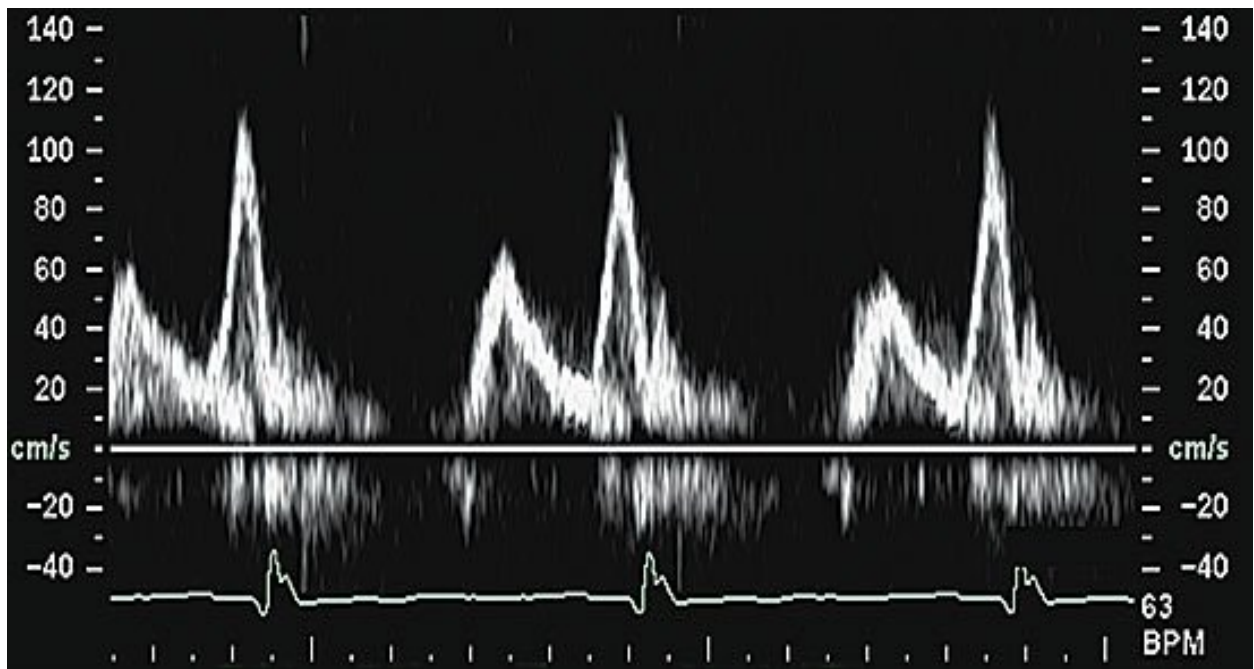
Trans-mitral-valve Doppler flow tracing in a patient with mild diastolic dysfunction (abnormal relaxation). The E-to-A-wave ratio is less than 1.0.
